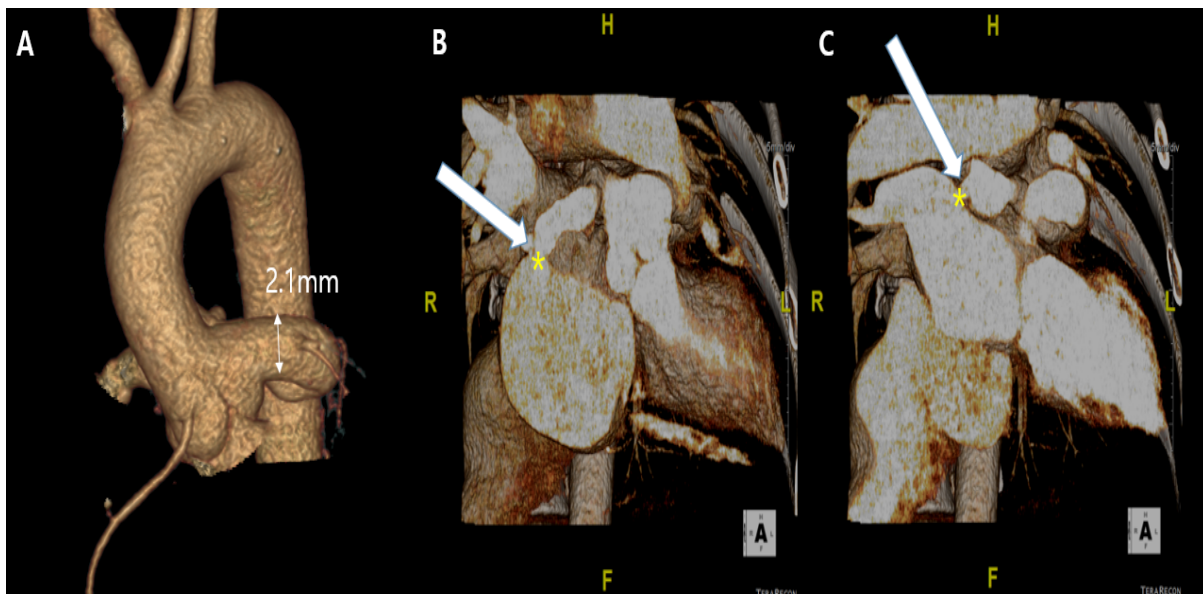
Coronary computed tomography angiography images showing a large left main artery (A) with fistulas in the right (B) and left atria (C).
